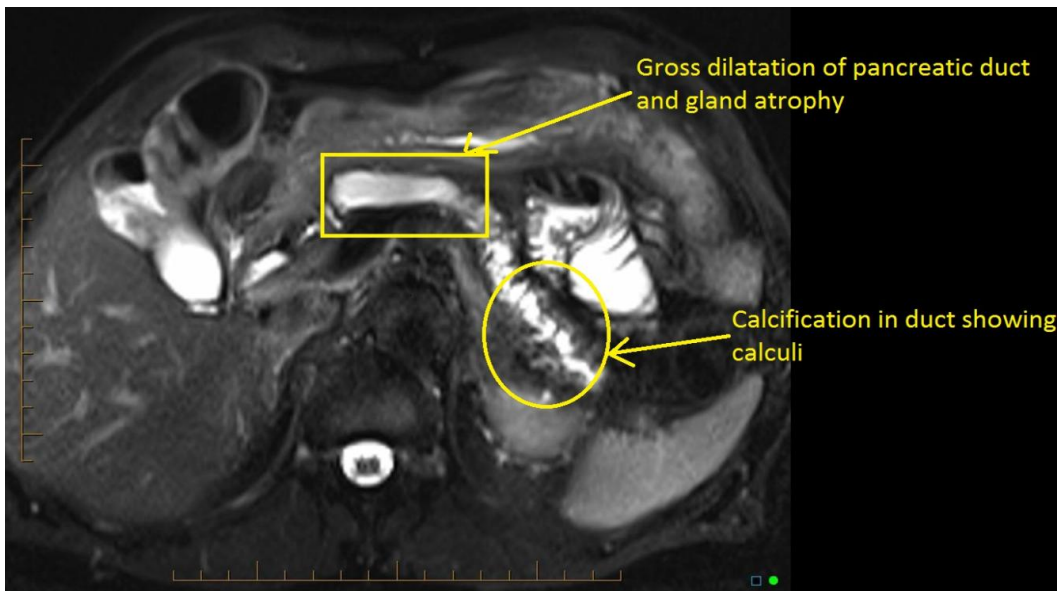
Hereditary pancreatitis MRI [32]
